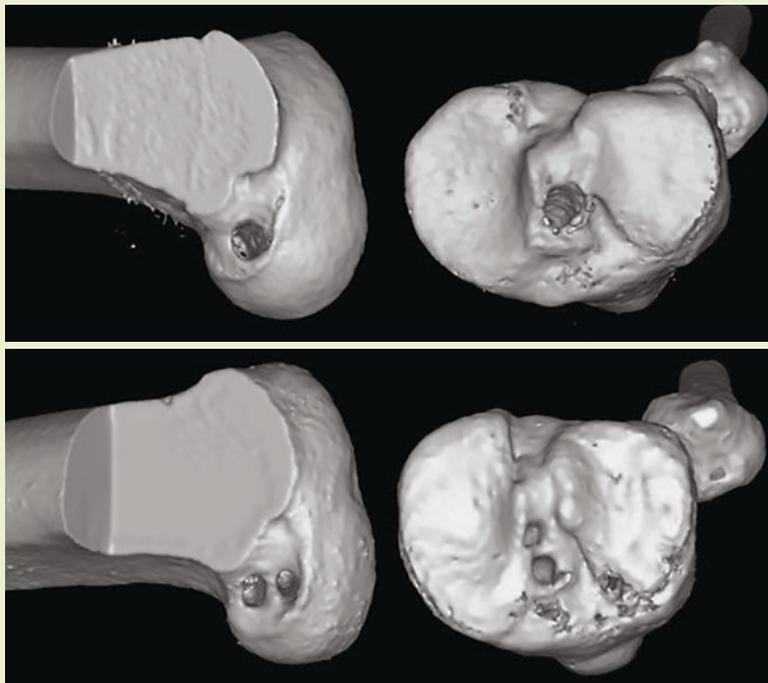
Postoperative computed tomography scan of a single-bundle ACL reconstruction (top), and double-bundle ACL reconstruction (bottom)
